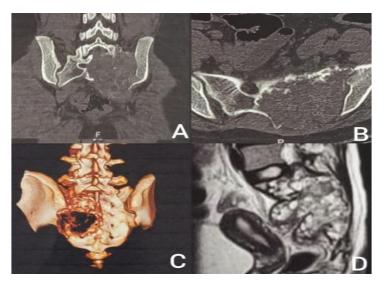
1B and 1C are non-contrast CT images of lumbosacral spine axial, coronal and 3D reconstruction respectively view demonstrated a large fairly well define lobulated heterogeneous lesion at sacrum S1-S4 segment replacing the left sacral bone with hyperdense internal septations within involving body, left sacral ala, left half of sacrum, left sided posterior neural arches with extension in sacral spinal canal, involving left sided sacral foramina and extending up to articular surface of left SI joint. Figure1D- Sagittal T2 weighted MRI image of lumbosacral spine showing fairly well defined solid-cystic lesion involving sacrum S1-S4 segments
